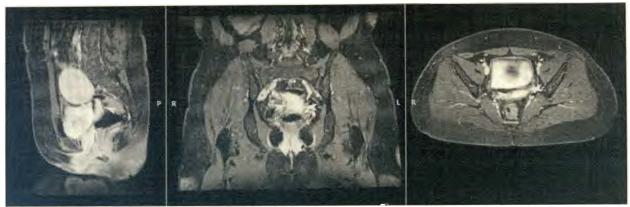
MRI of the pelvis: A nodular, T1W-/T2WI-isointense focus, with no restricted water diffusion and magnetic susceptibility artifact, is seen intimately related to the left posterolateral aspect of the uterus, measuring approximately 1.3cm x 1.6cm (W x AP). This may represent the aplastic cervix.
